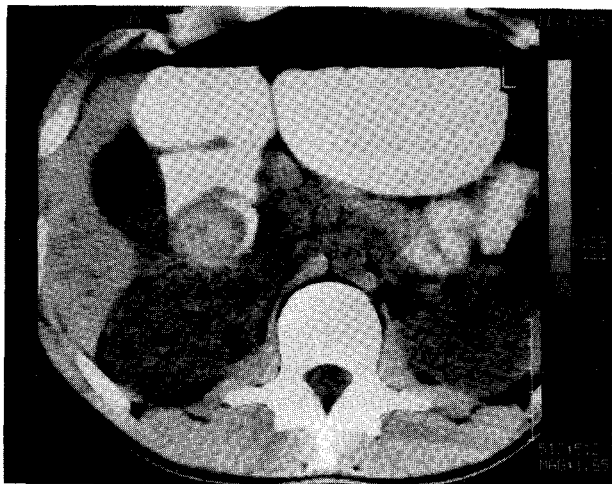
Computed tomography demonstrating an intramural haematoma of the second part of the duodenum.
